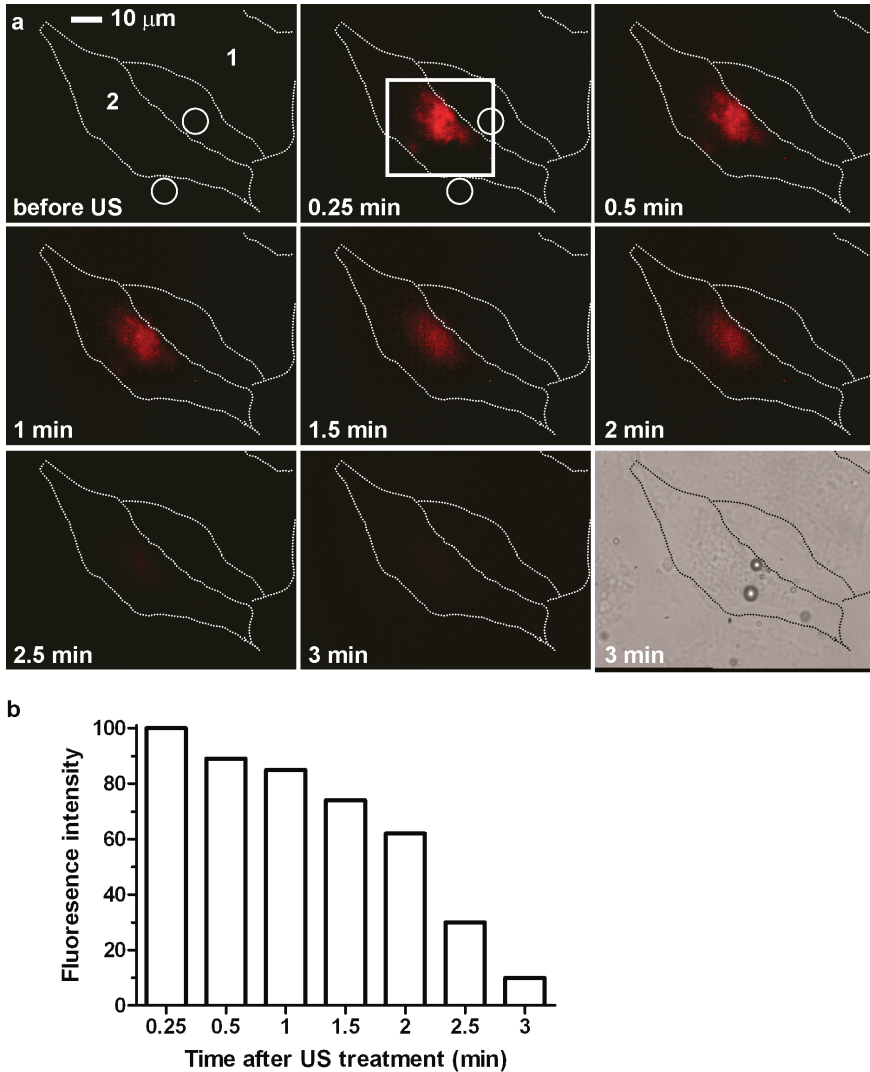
PI uptake. a) Fluorescence and bright field images of PI uptake of two cells before and after insonification; same cells-bubbles as in Fig. 2.3. Circles in fluorescence images indicate position of microbubbles; US = ultrasound. Square in middle top image: region of interest. b) Relative fluorescence intensity after insonification in region of interest of deformed cell 2 as percentage of the first fluorescent image at $t = 0.25$ min after insonification.
